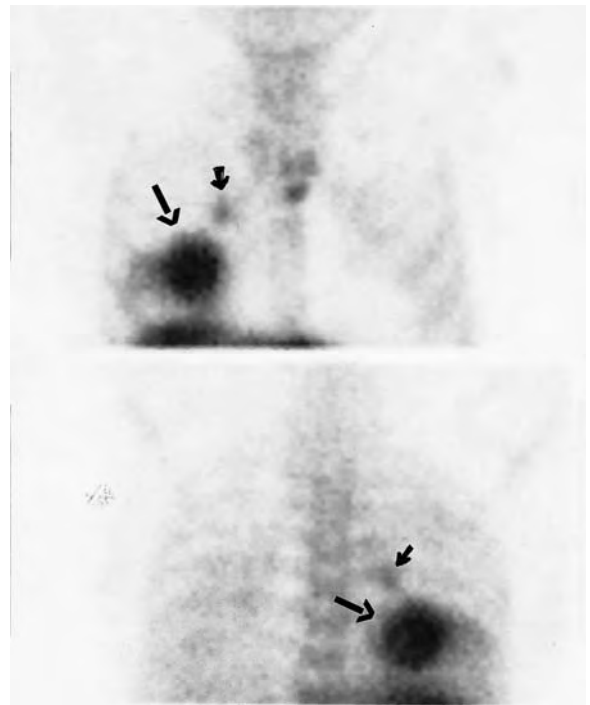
^{99m}Tc -P829 scintigraphy indicates in a patient with non-small-cell lung carcinoma (NSCLC) the tumor sites at 90 min after injection of 50 μg (600 MBq) radioligand. Planar imaging: anterior (*top panel*) and posterior (*bottom panel*) views. In addition to the large tumor mass (*long arrow*) a small lymph node metastasis was identified above the tumor lesion (*short arrow*) which was not identified on CT but was verified by surgery
